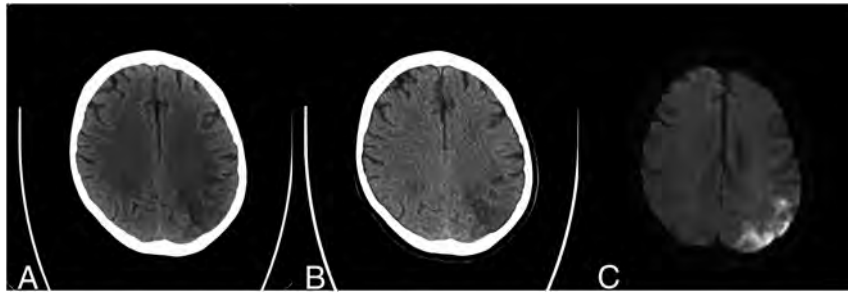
A sample case of a 66-year-old male patient who presented with right-sided weakness and numbness (NIHSS 7). His medical history included diabetes mellitus, hypertension, hyperlipidemia, prior smoking, and prior ischemic stroke, for which the patient used dual-antiplatelet therapy. The time between last seen well and CT was 14 hours. The time between CT and DWI was 12 hours. Conventional NCCT (A) and virtual NCCT (B) show early ischemic changes in the left parietal lobe (ASPECTS region M6). In the same region, DWI (C) shows hyperintensity, indicating diffusion restriction compatible with ischemia.
